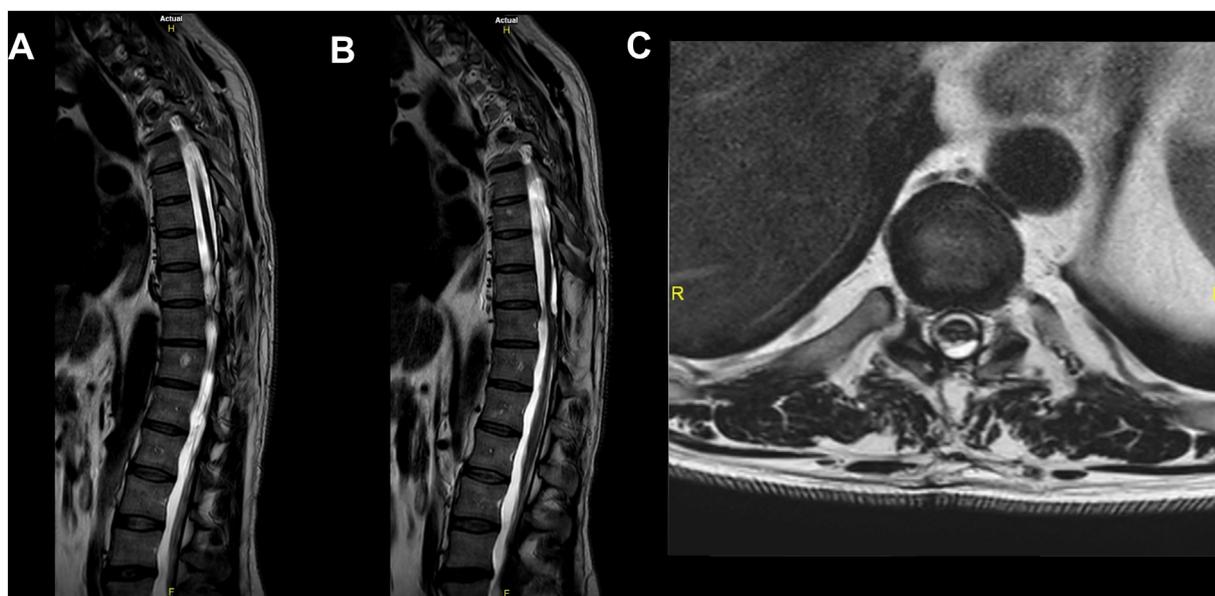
Dorso-lumbar spine MRI on sagittal axis T2-weighted (A,B) and D9 transversal slice (C). A and B shows spinal atrophy and epidural cyst between D9-D10.
